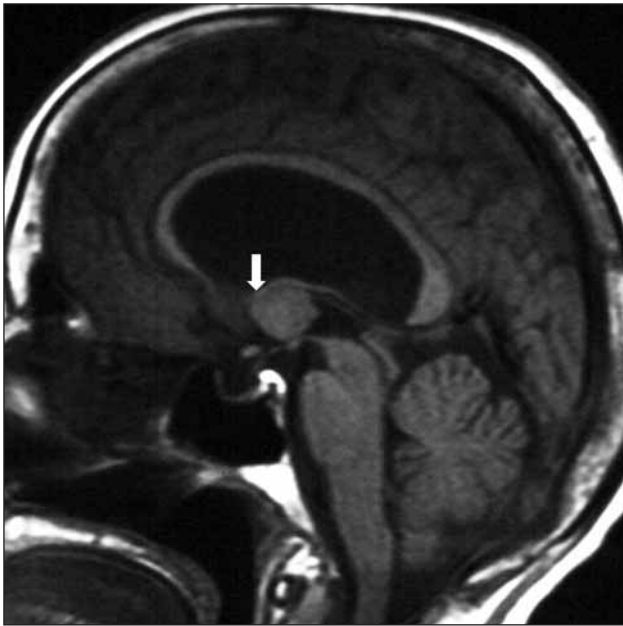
MRI shows almost half of the cyst was located posterior to the foramen of Monro. (White arrow shows the posterior border of the foramen Monro.)
